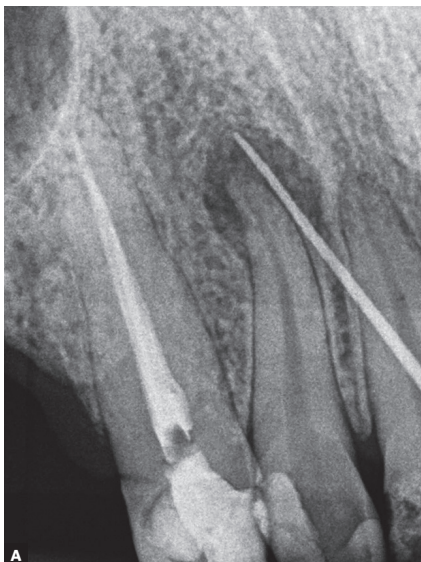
Radiographic screening.
